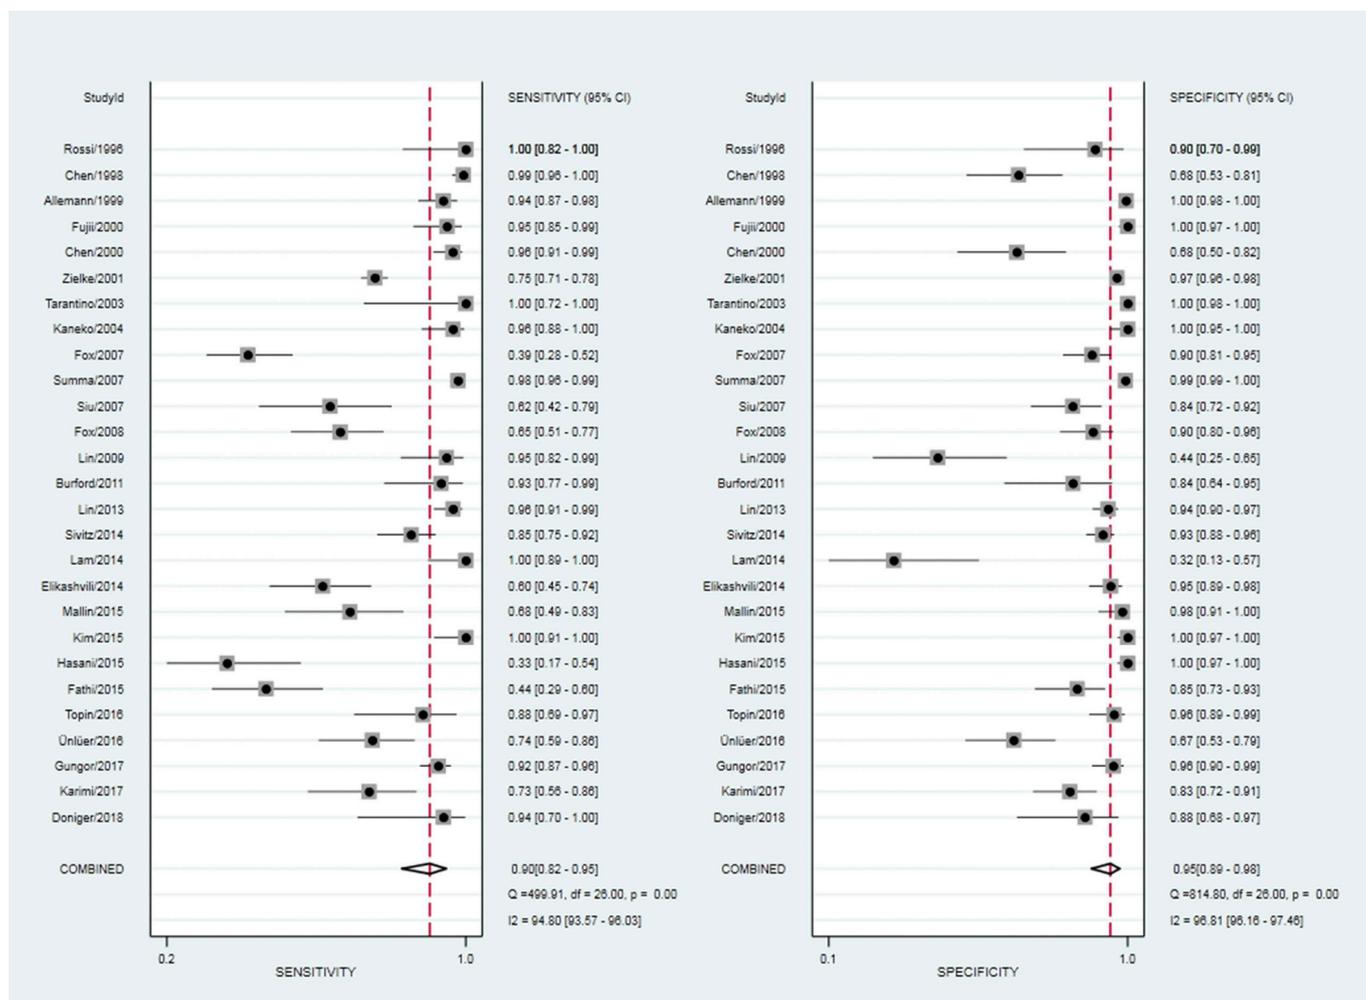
Sensitivity and specificity of bedside ultrasonography for diagnosis of acute appendicitis.
